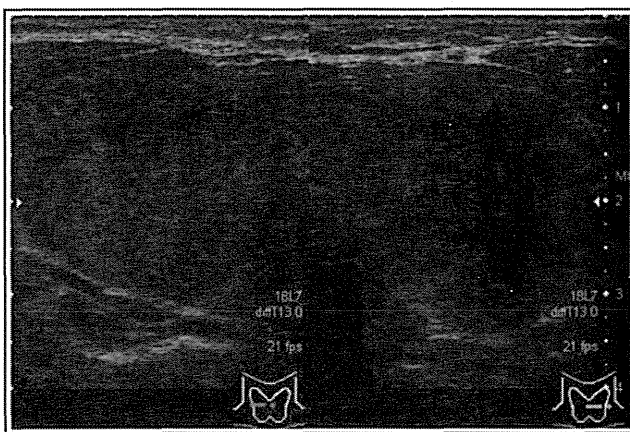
An ultrasonographic image of patient 3. Note that hypoechoic areas are seen throughout both lobes of the thyroid gland.
